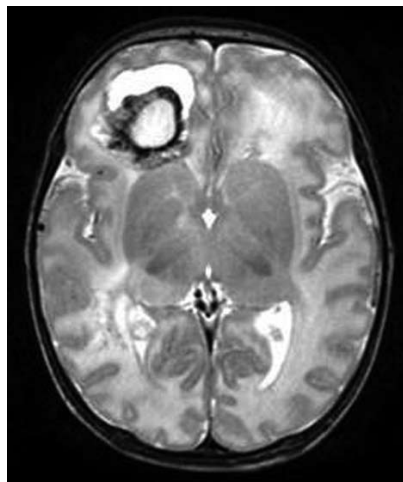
T2-weighted MRI showing a large hemorrhagic abscess in the right frontal lobe
